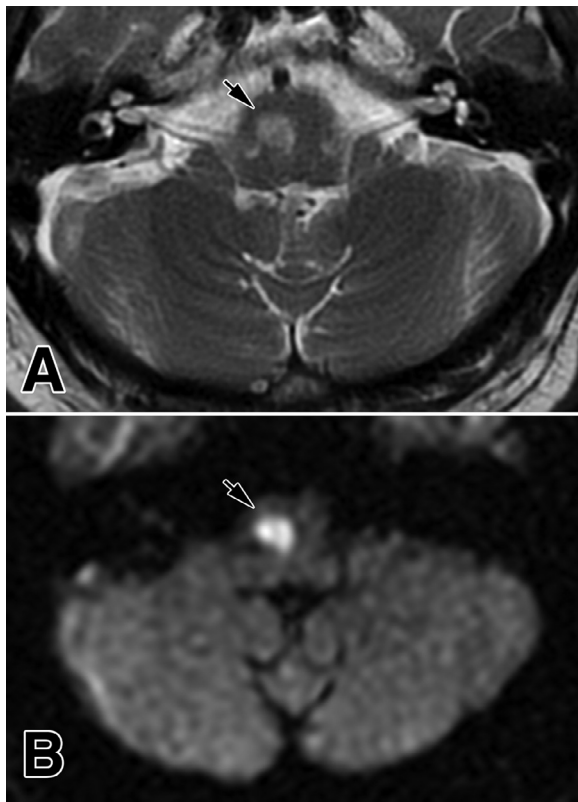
A right common central medial and deep lateral infarction (arrows) of the upper medulla in the axial T2-weighted (A) and DWI (B) images at the level of the vestibulocochlear nerves.
